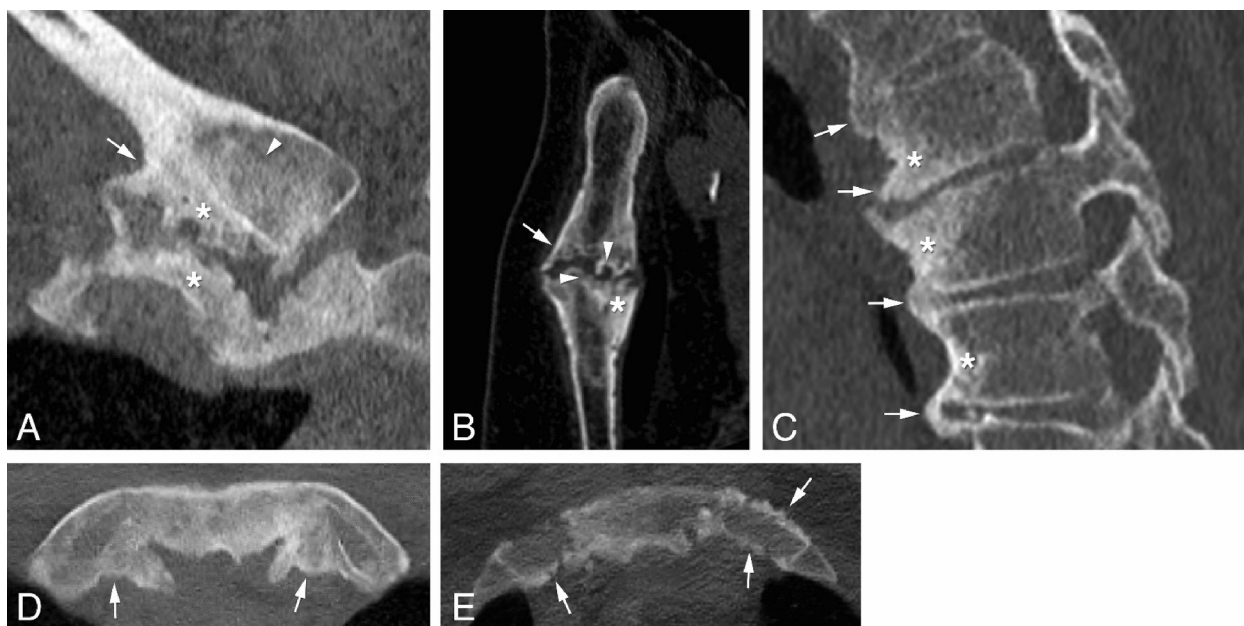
Examples of common locations of hyperostosis in adult CNO and pitfalls. A: (coronal CT view) hyperostosis in the medial end of the right clavicle (arrow), associated with sclerosis (arrowhead) and calcifications-ossifications of the costoclavicular ligament (asterisks). B: (sagittal CT view) hyperostosis in the manubrium-corpus sterni joint (arrow), together with sclerosis (asterisk) and erosive changes (arrowheads). C: (sagittal CT view) hyperostosis (with at some levels also ankylosis) in the thoracic spine, at the level of the anterior vertebral ligament (arrows), with associated sclerosis in adjacent vertebra (asterisks). This association would not be seen in DISH. D: (axial CT view) example of bridging hyperostosis, with osteosclerosis, and complete ankylosis of the first anterior costosternal joints on both sides (arrows) in CNO. E: (axial CT view) example of bilateral hypertrophic ossifications (common pitfall) affecting the costochondral and sternocostal (SC) junctions of the first rib, more prominent on the left side (arrows). Associated sclerosis of the adjacent sternum is not seen.
